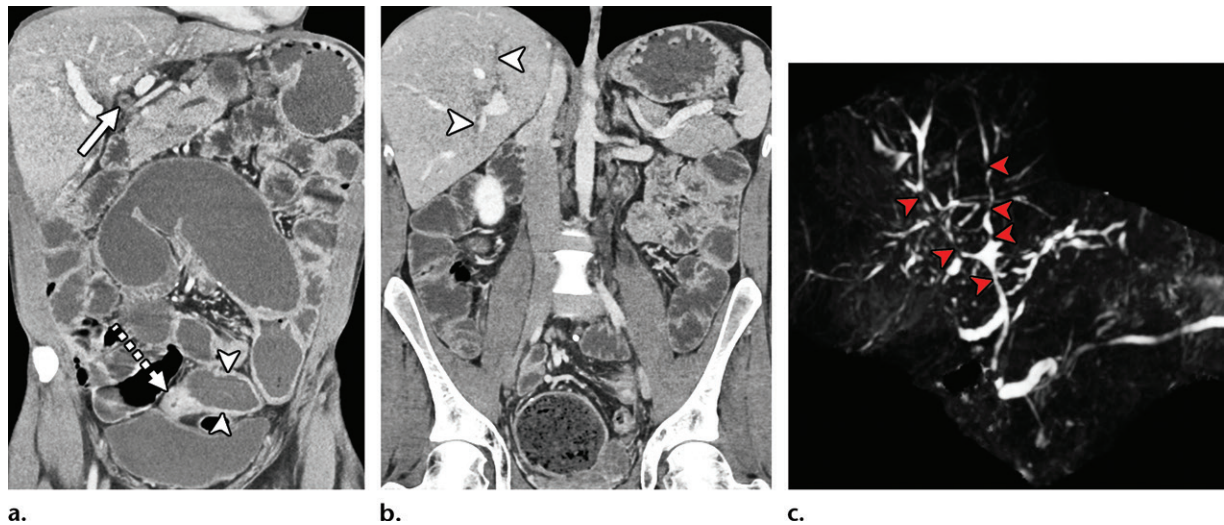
Biliary complications. (a, b) Coronal contrast-enhanced CT enterographic images with neutral oral contrast material in a patient with Crohn disease show common hepatic duct wall thickening (solid arrow in a) and irregular intrahepatic biliary duct dilation (arrowheads in b), findings concerning for a primary sclerosing cholangitis (PSC) diagnosis. Note the wall thickening, mural hyperenhancement, and luminal narrowing in a segment of ileum in the pelvis (dashed arrow in a) with upstream bowel dilation (arrowheads in a), findings consistent with a stricture with active inflammation. (c) Follow-up coronal maximum intensity projection MR cholangiopancreatographic image confirms the diagnosis of PSC and shows multiple intrahepatic and extrahepatic bile duct strictures (arrowheads).
